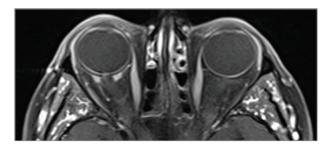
T1 axial orbital magnetic resonance image with gadolinium following radiotherapy treatment of the right orbit, demonstrating an interval size reduction of the enhancing optic nerve mass and resolution of the retinal detachment.
